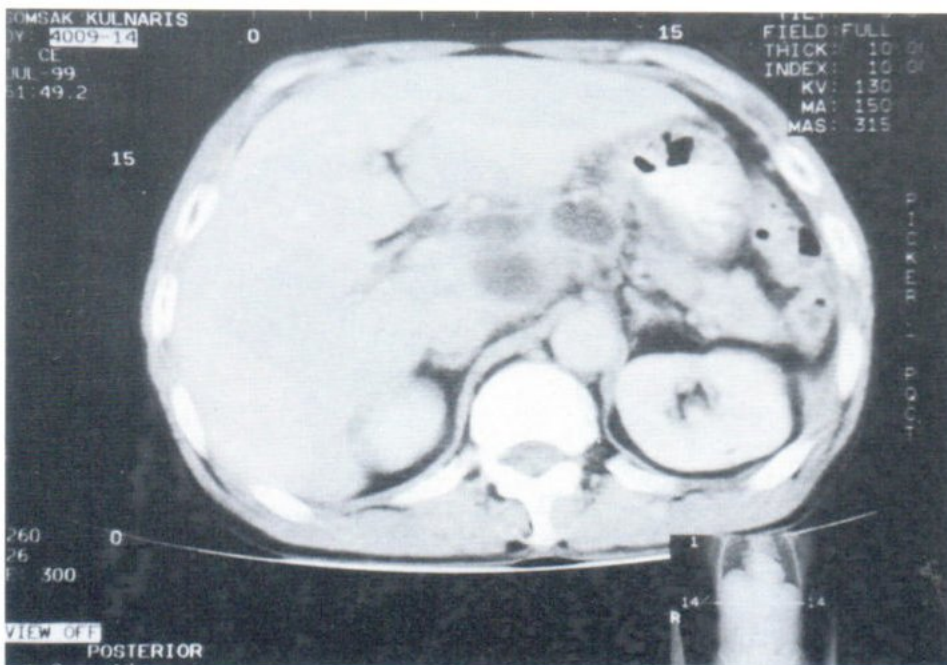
Small pseudocysts at pancreatic body, the inferior portion of pseudocyst at the superior recess of omental bursa is also seen in this CT slice.
